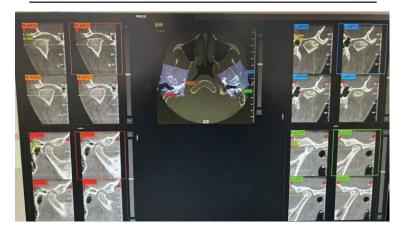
CT examination of the joints of the upper and lower jaw of patients (malocclusion)
